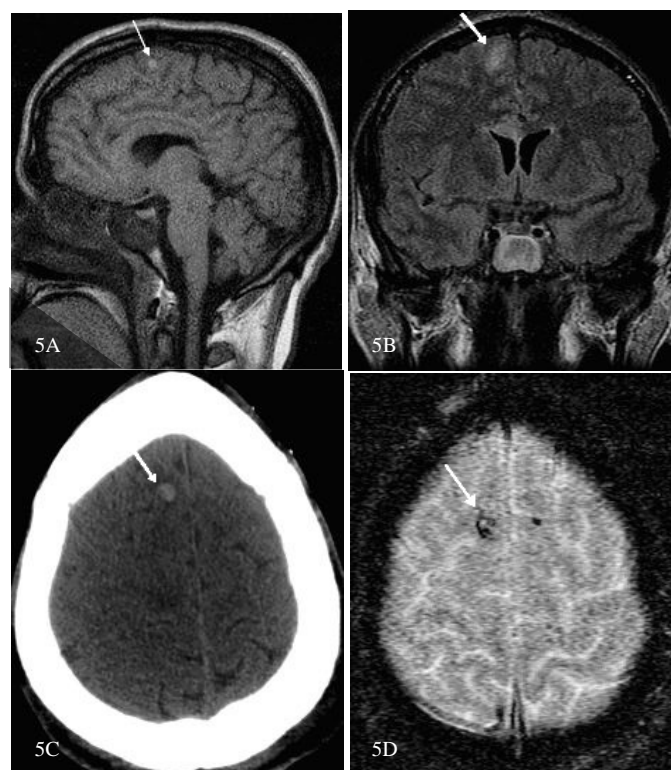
Sagittal T1-weighted image (A) showing a small focus in right frontal lobe at the gray-white junction, consistent with methemoglobin (arrow). Coronal FLAIR (B) at the corresponding site shows focal high signal (arrow) consistent with a small area of edema. NECT (C) shows small round hemorrhagic focus in the right frontal lobe (arrow). GRE sequence (D) showing associated blood product (arrow) in same region.
